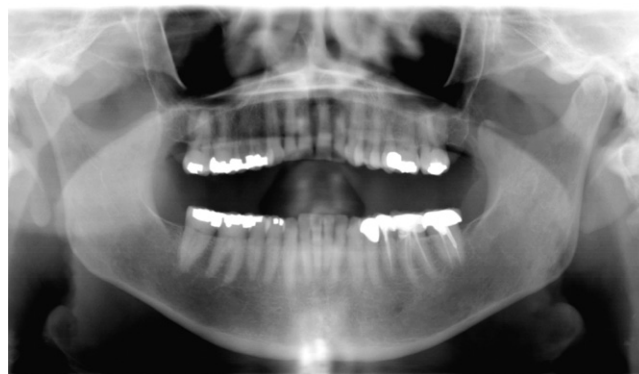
Rheumatoid arthritis affecting the TMJ. The panoramic radiograph of this patient shows evidence of degenerative changes on the right TMJ, exhibiting flattened condyle and narrowing of the right joint space. Clinically the patient presented with a 2-mm posterior open bite.
